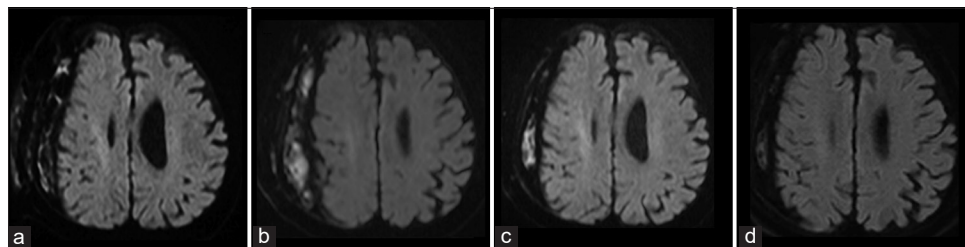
Head diffusion-weighted magnetic resonance imaging confirms a gradual decrease in the hyperintense signals (indicating the abscess) and, finally, the complete disappearance of the infected subdural hematoma. (a) Two days after surgery, (b) 1 month later, (c) 3 months later, and (d) 6 months later.
